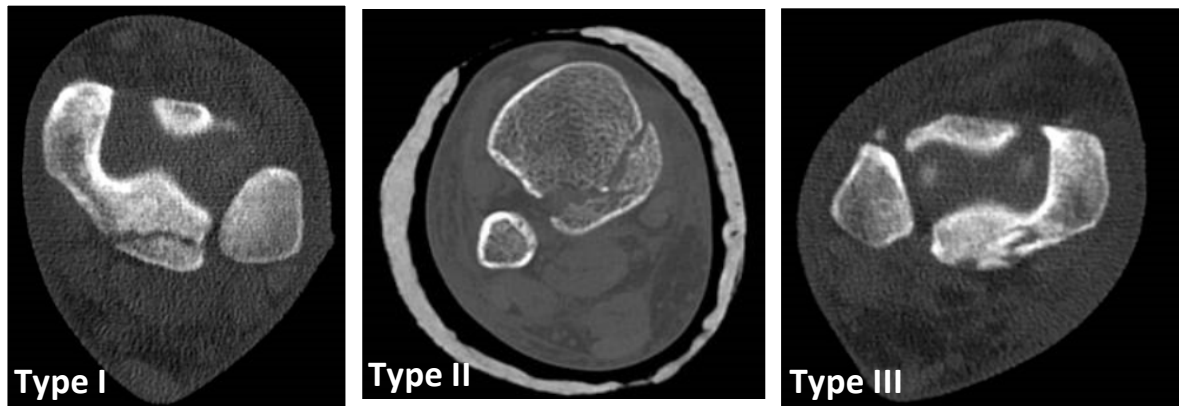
CTs from Paper III; Haraguchi type I, II and III fracture on axial CT scan. Department of Radiology, Bærum Hospital.
